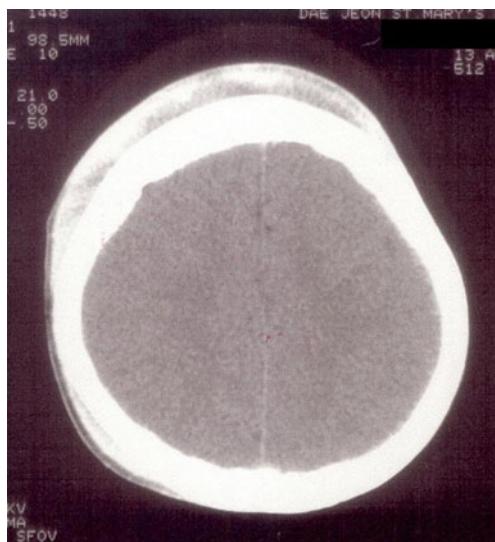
Initial brain CT scan showing a scalp hematoma in both frontal areas with dominance on the right side. No skull fractures or intraparenchymal lesions were noted
